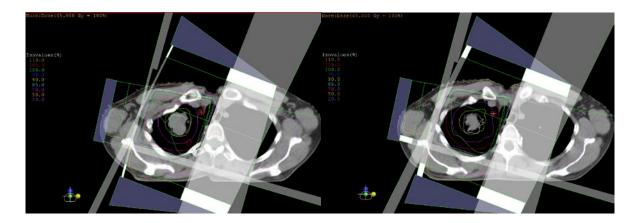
Planning CT images with contoured macroscopic lung cancer as GTV (yellow line), the planning target volume as PTV (red line) before the RT (left picture); the shrinked tumour volume as GTV1 (blue line), the new PTV as PTV1 (pink line) after 45 Gy irradiation (right picture), therapeutic beams and isodose curves.
